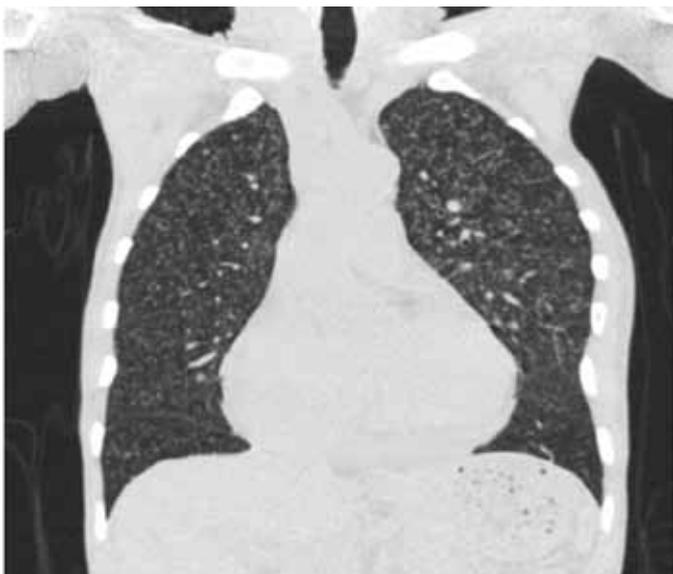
Computed tomography scan of the chest without contrast (coronal view) showing multiple diffuse tiny nodules (2–3 mm) seen throughout both lung fields.
